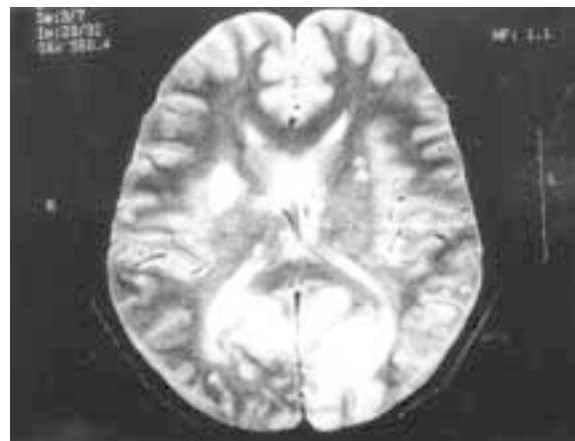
T₂ weighted MR image (SE TR 2200/90/1 nex/ 256x192) in axial plane reveals hyperintense lesions with profound perilesional oedema.
